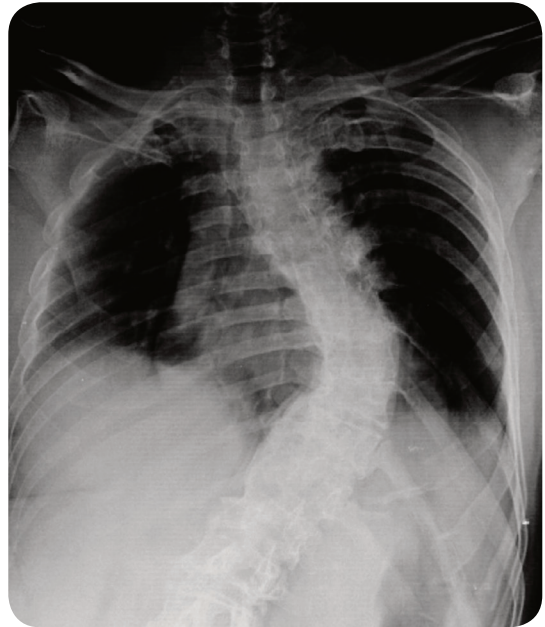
A plain chest radiograph demonstrating spinal scoliosis.
